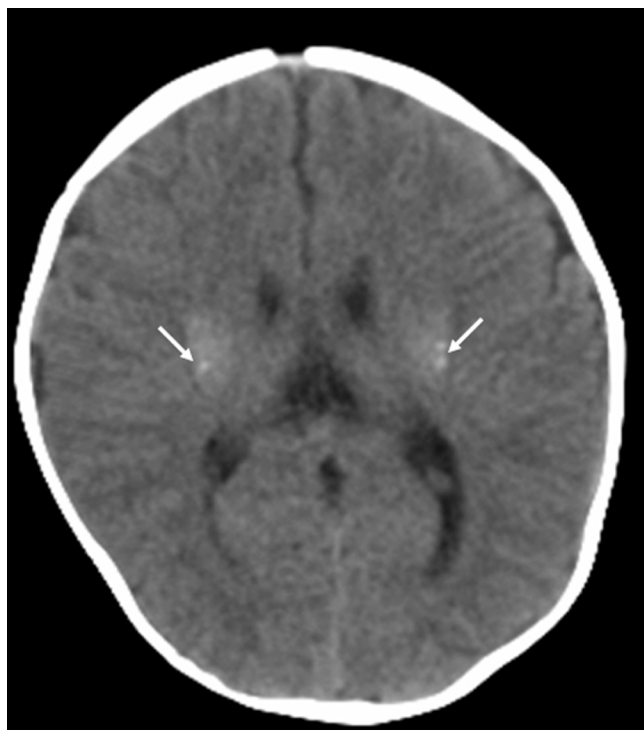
CT scan revealing mineralization in the lateral thalami and posterior putamen.
